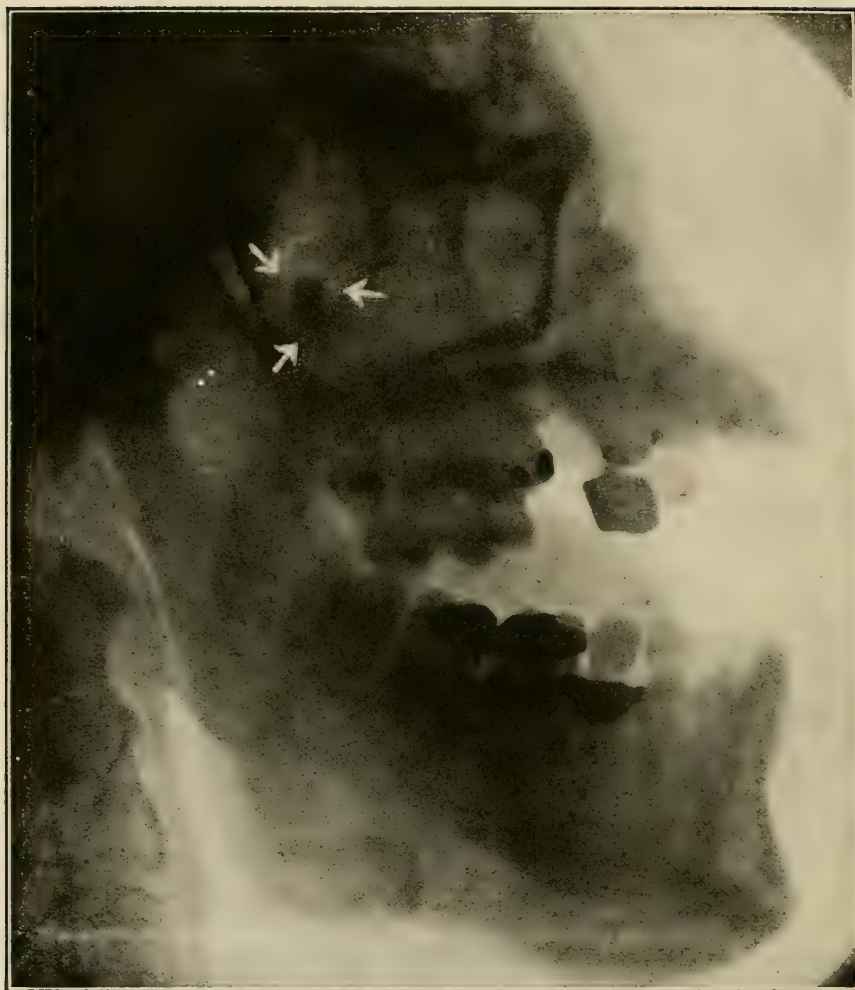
The arrows point to a piece of tooth root in the antrum. (Radiograph by Carman, of St. Louis.)
